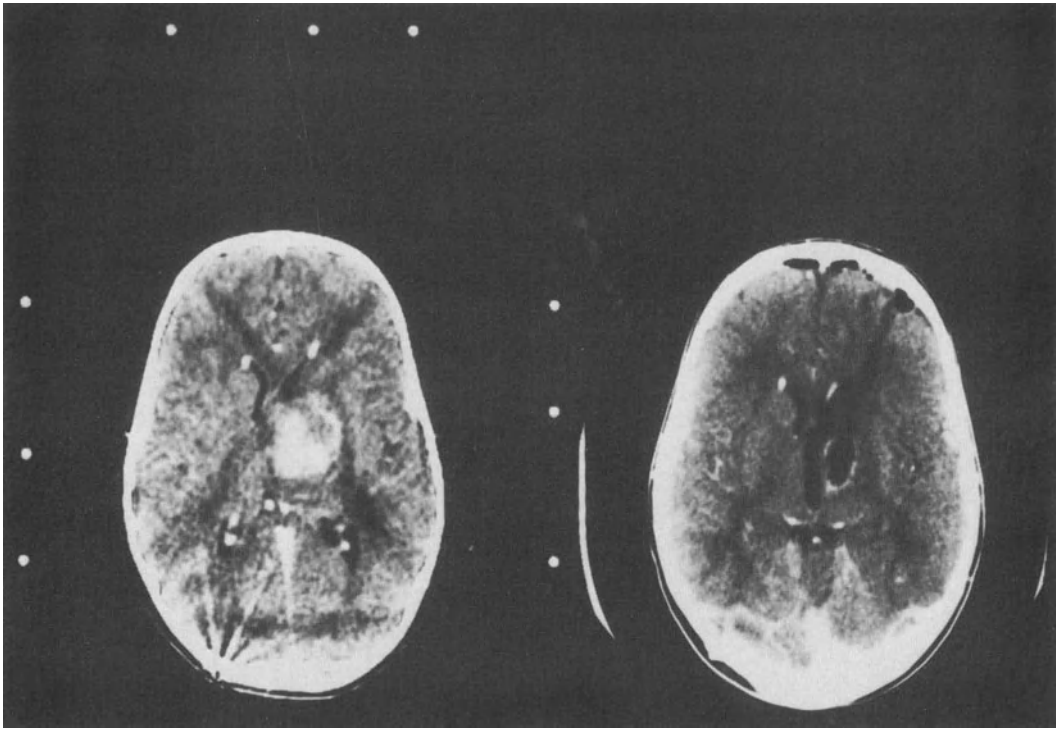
Preoperative and postoperative CT scans in a left thalamic mass with associated hemorrhage.
